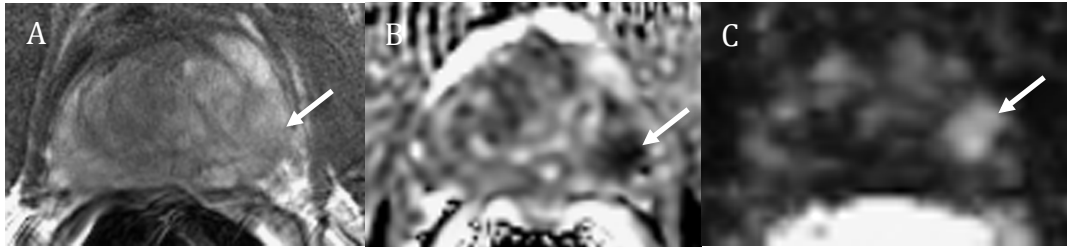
A 60 year-old male with serum PSA of 9.3 ng/ml who underwent radical prostatectomy. Sparse GS4+5 cancer (20% cancer) as seen on: a) coil-corrected T2-weighted image, b) ADC map C) maximal enhancement slope. The arrows designate cancerous regions.
